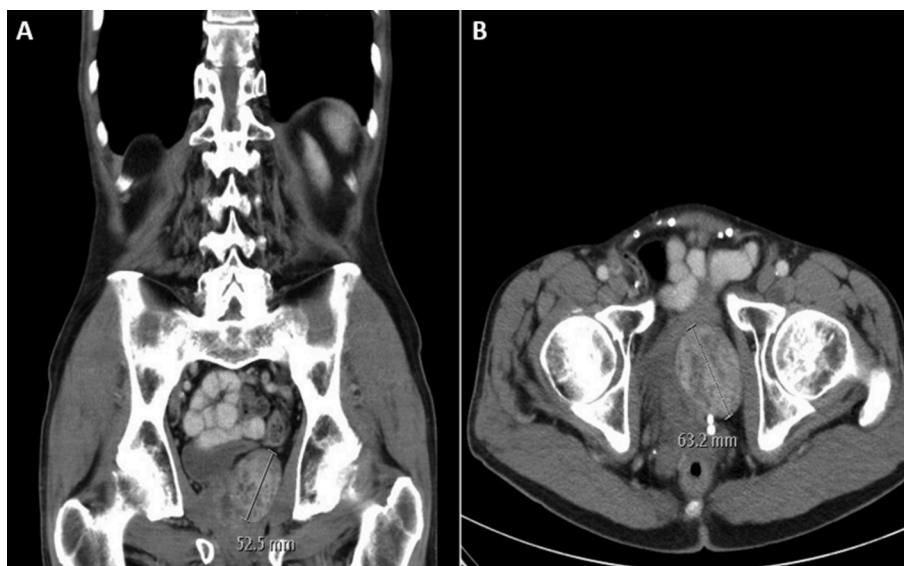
CT Imaging of a Periprostatic SFT. A) Coronal CT image and B) Axial CT imaging shows a large left side periprostatic mass with heterogeneous enhancement and mass effect on surrounding structures.
